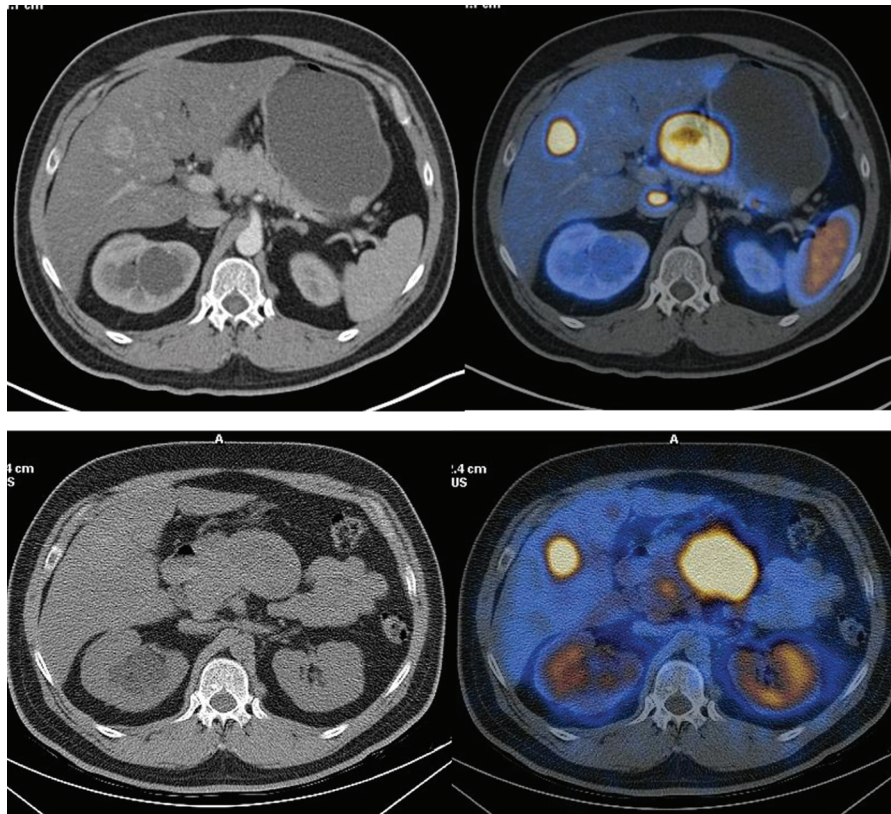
A: $[^{68}\text{Ga}]\text{Ga-DOTANOC}$ PET/CT demonstrate tracer avid lesion in segment V of liver and sub-hepatic region. B: $[^{99\text{m}}\text{Tc}]\text{Tc-HYNC-TATE}$ demonstrate tracer avid lesion in segment V of liver and sub-hepatic region.
